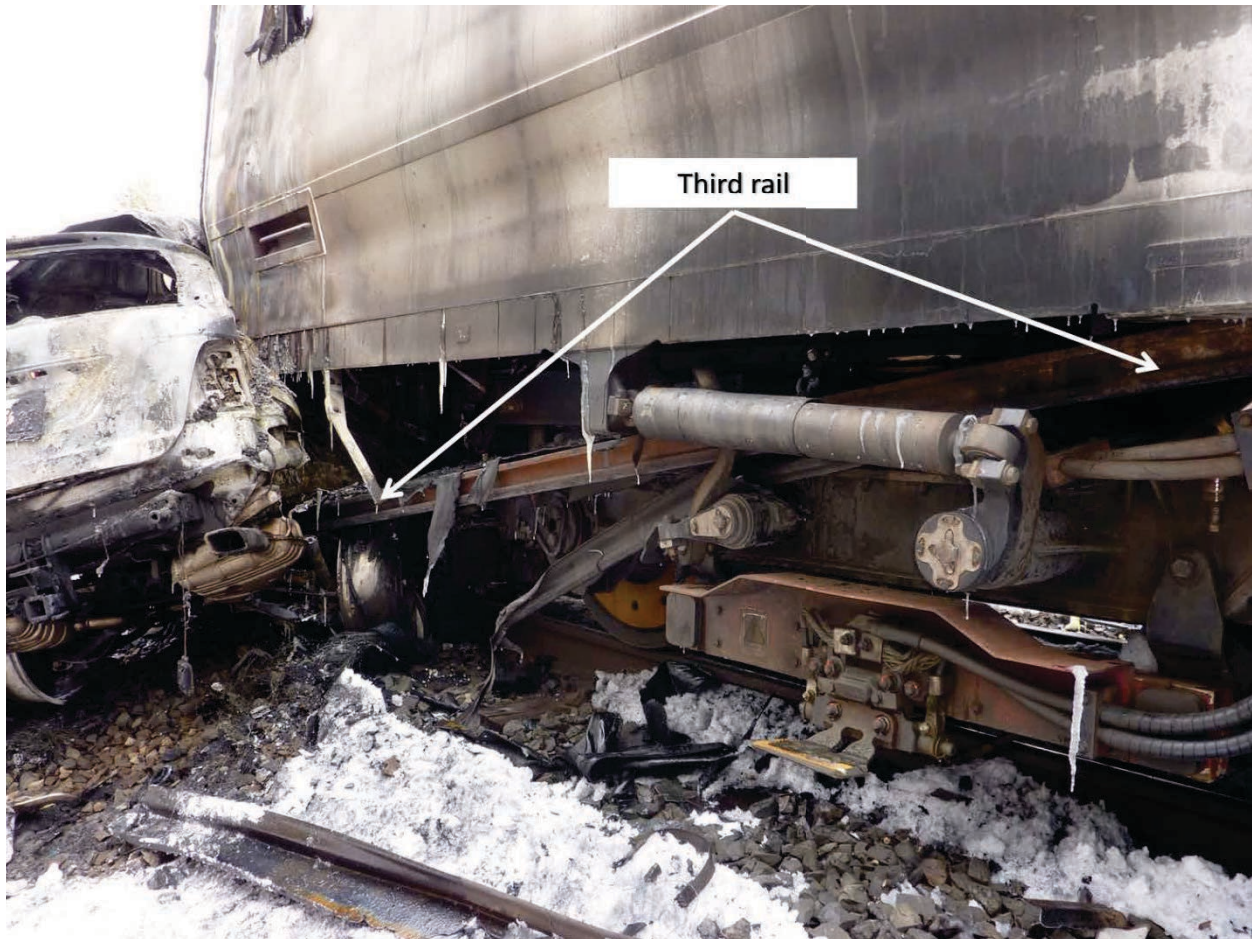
Photograph of the SUV and Metro-North train 659 after the collision.
